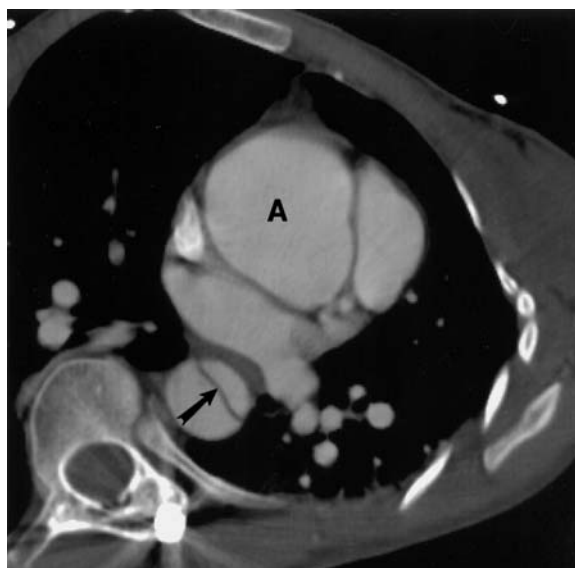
Annuloaortic ectasia and dissection secondary to Marfan's disease. Axial CT scan shows a dilated proximal descending aorta (A) and an intimal flap (arrow) in the distal descending aorta, due to an acute dissection
